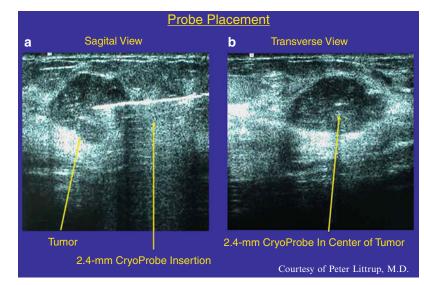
Ultrasoundguided placement of a cryoprobe in a breast fibroadenoma, (a) sagittal and (b) coronal views
